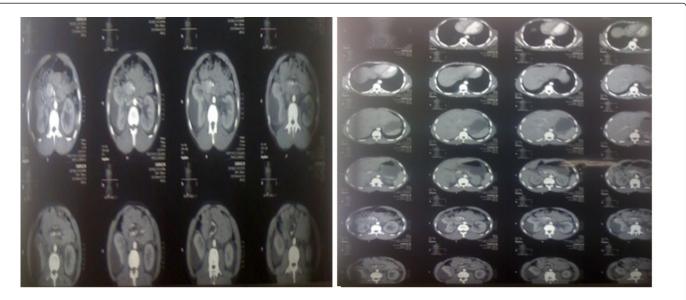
CT scan abdomen with special section taken of renal area (Transverse and Longitudinal).
